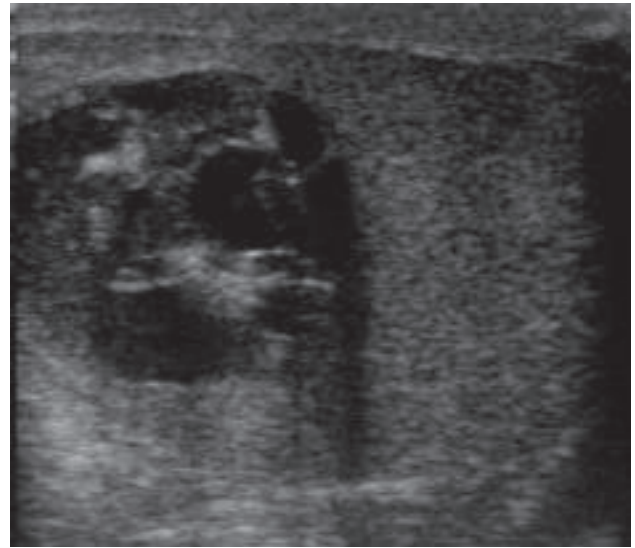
Ultrasound image in Case 2, showing testicular lesion with heterogeneous echogenicity. In this case, the tumor was enucleated under cord clamping.
